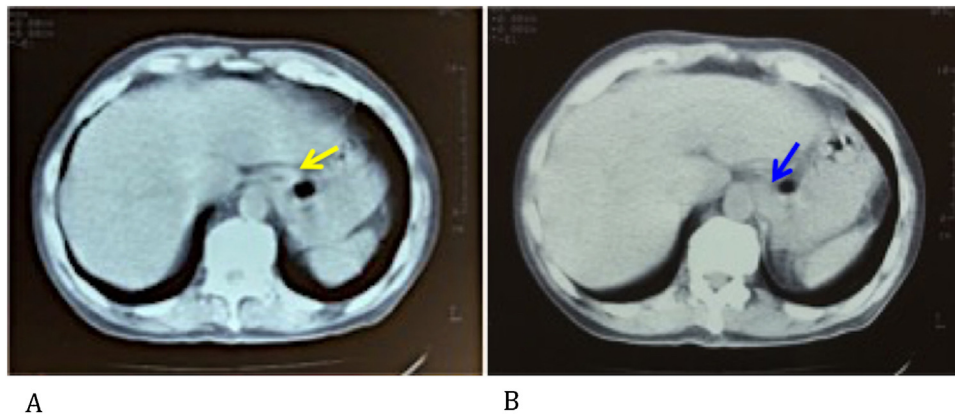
Contrast-enhanced CT scan images demonstrating A: EGJ wall thickening (yellow arrow) and B: EGJ wall thickening extending to proximal gastric portion (blue arrow) with no enlarged lymph nodes and no liver metastases.
